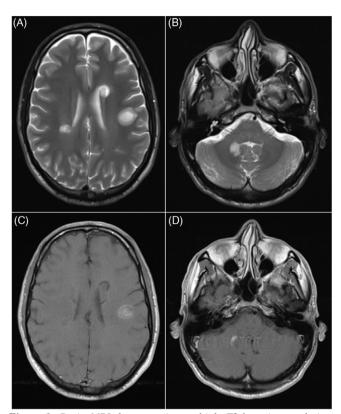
Brain MRI demonstrating multiple T2-hyperintense lesions with concentric ring pattern within supratentorial region (A) and one within the infratentorial right cerebellum (B); corresponding brain MRI post-contrast T1-enhancing lesions demonstrating active disease (C and D).
